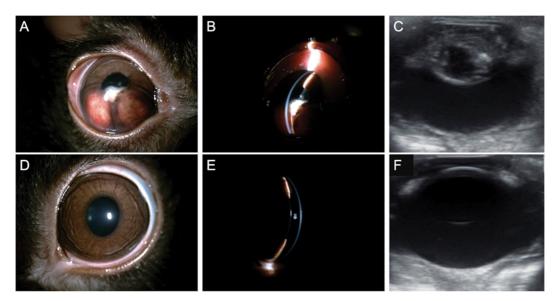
Initial presentation and ocular ultrasonographic images. (A-C) Right eye. (D-F) Left eye. Compared with the normal left eye, the right eye showed a white mass in the ventral portion of the pupil, behind the iris. Ocular B-scan ultrasonography revealed hyperechoic material within the anterior chamber connected with the anterior lens capsule with immature cataract in the right eye.
